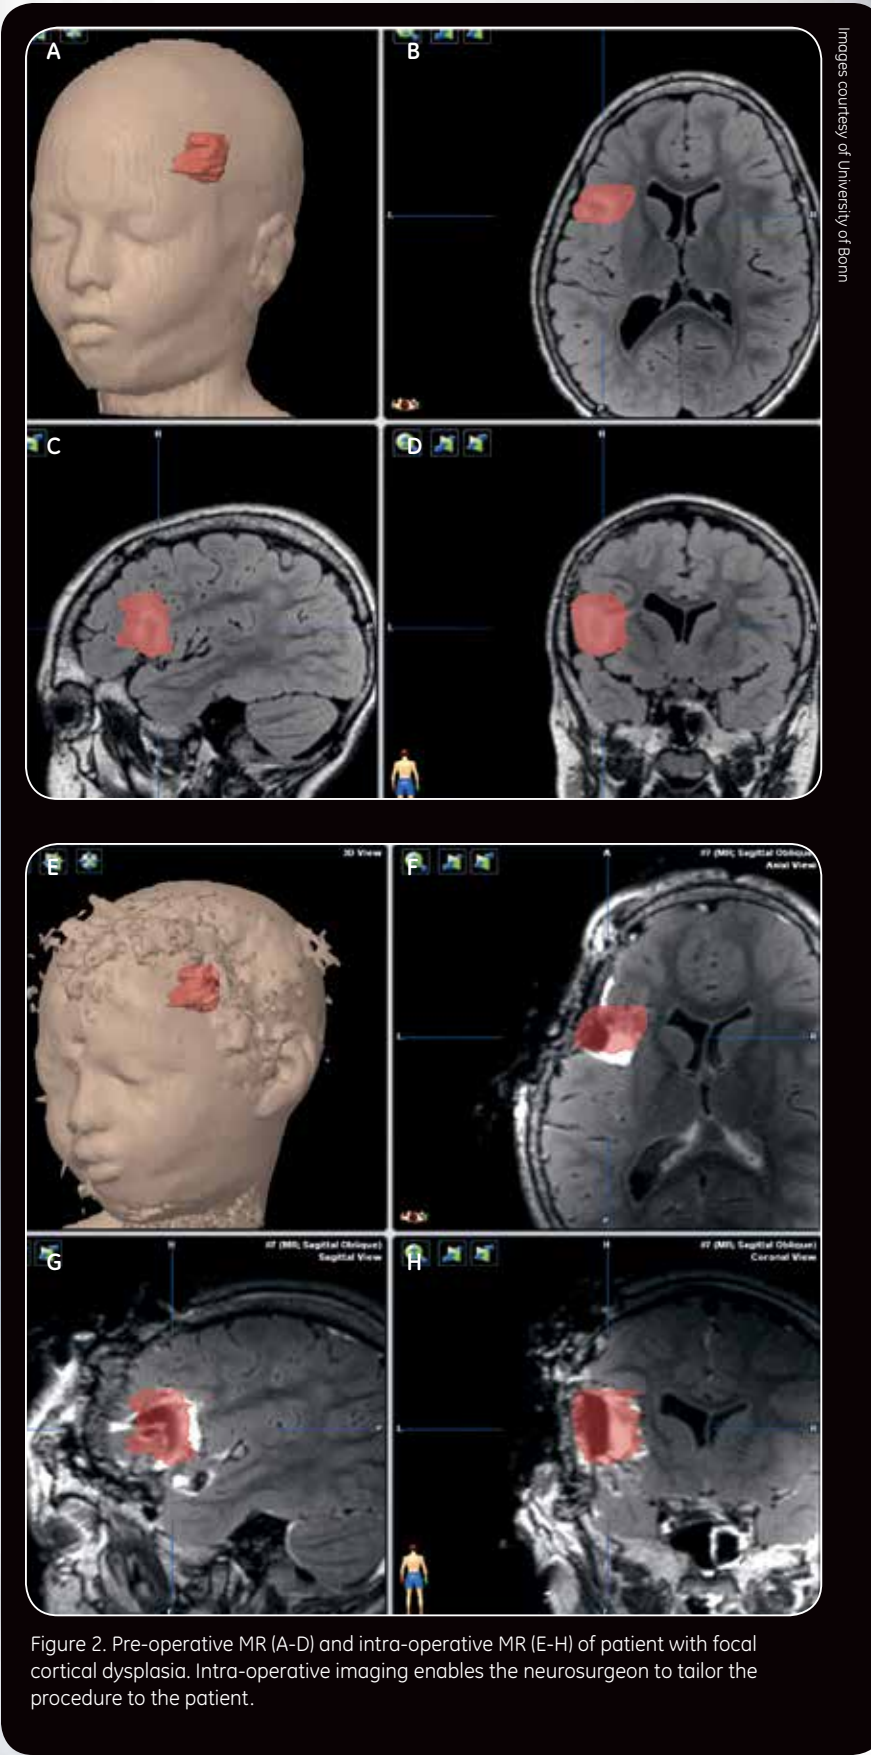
Pre-operative MR images (top row) used for surgical planning; intra-operative MR images (bottom row) showing active contrast leakage into the surgical bed.
